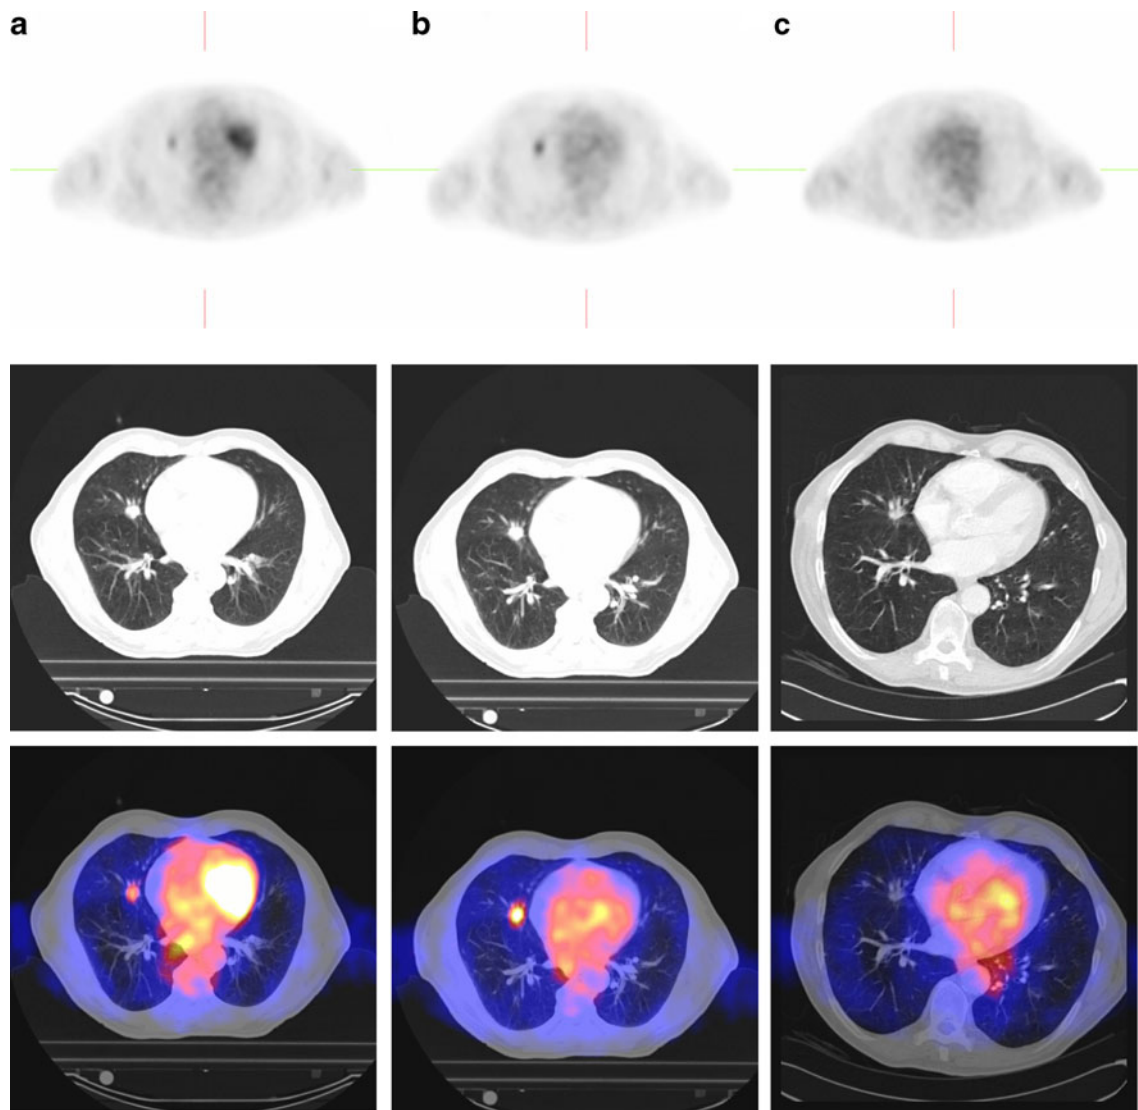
Sequential axial PET (*upper row*), CT (*middle row*) and fused PET/CT (*lower row*) images of patient 3, before (a), after the first fraction (b) and 12 weeks after SBRT (c). SUV_{max} increased from 6.3
